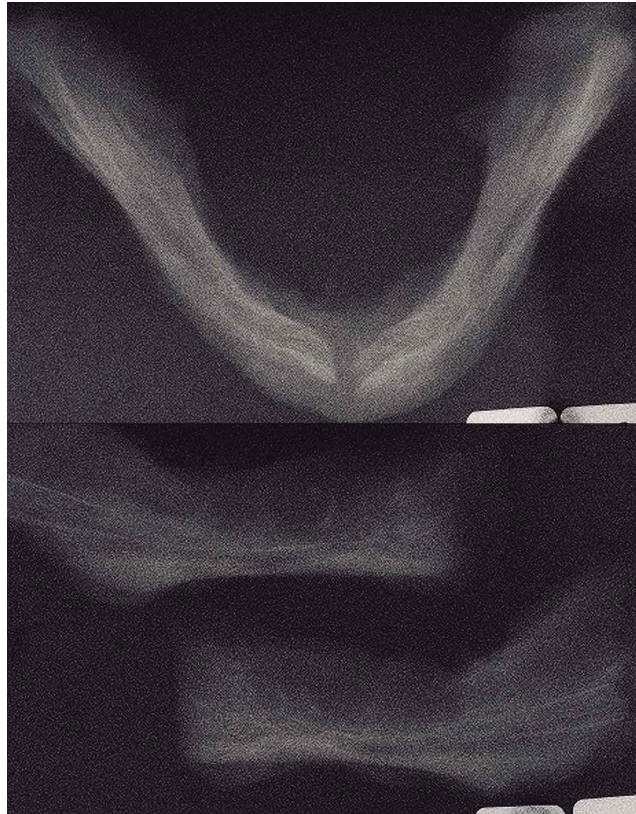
Radiographs of the 26-weeks fetus mandible. Figure above – Occlusal incidence - Note the inner and outer corticals of the mandibular canal and the no-fusion of symphysis in the median line. Figure below – Lateral incidence - See the superior and inferior corticals of mandibular canal and the higher intensity of bone mineralization in the anterior region of the inferior margin of mandible.
